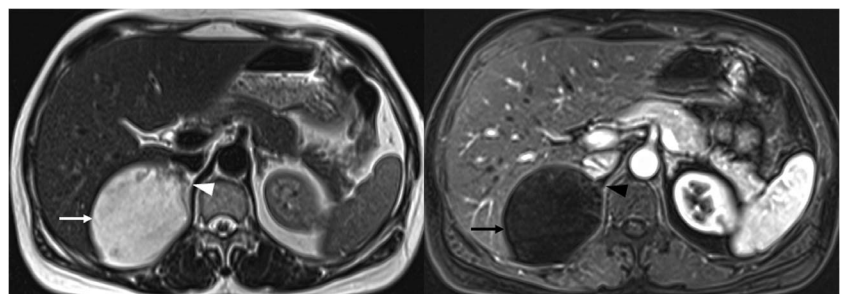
MRI shows adrenal myelolipoma (arrow) and the adrenal gland (arrowhead).
